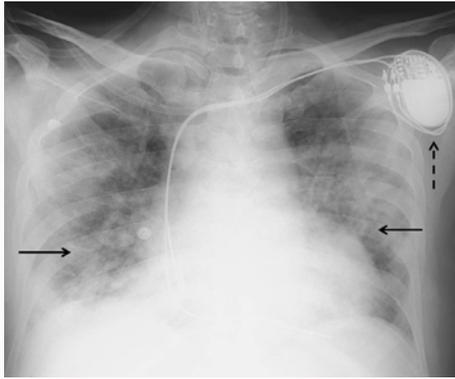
AP chest radiograph of 57-year-old male, known case of cardiac arrhythmia; with diffuse air space opacification bilateral lung fields (black arrows). Note the presence of pacemaker *in situ* (dashed arrow).
